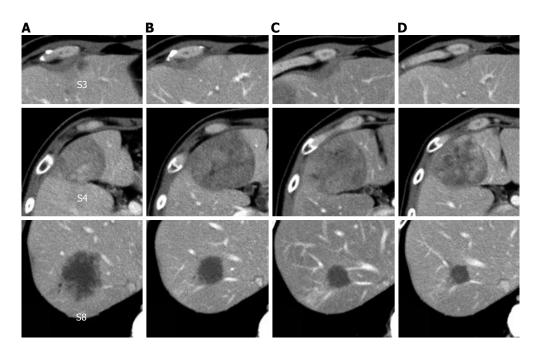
Change in tumor size observed using computed tomography during the clinical course. A: Before treatment; B: After six courses of modified FOLF-OX6 plus bevacizumab; C: After seven courses of FOLFIRI plus bevacizumab; D: After one course of ininotecan plus cetuximab.
